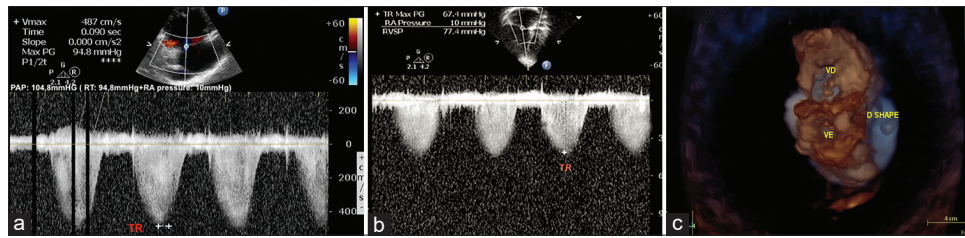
Echocardiography showing a decrease in the pulmonary artery systolic pressure from 104.8 mmHg before the initiation of selexipag (a) to 78 mmHg after 3 months (b). Pulmonary artery systolic pressure was calculated using the following formula: PAP = tricuspid regurgitation gradient (TR) + RA pressure (RAP) = 10 mmHg. PAP: Pulmonary artery systolic pressure; TR: Tricuspid regurgitation gradient; RAP: Right atrial pressure (c) 3D echocardiography showing the crescent-shaped LV (“D-shaped” LV) before selexipag initiation. 3D: Three dimensional; RV: Right ventricle; LV: Left ventricle
